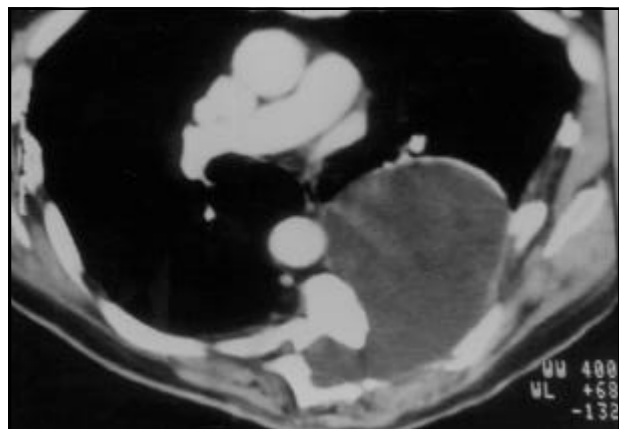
A transversal thorax CT scan showed a big cystic mass on the left hemithorax with continuous at the spinal canal.
